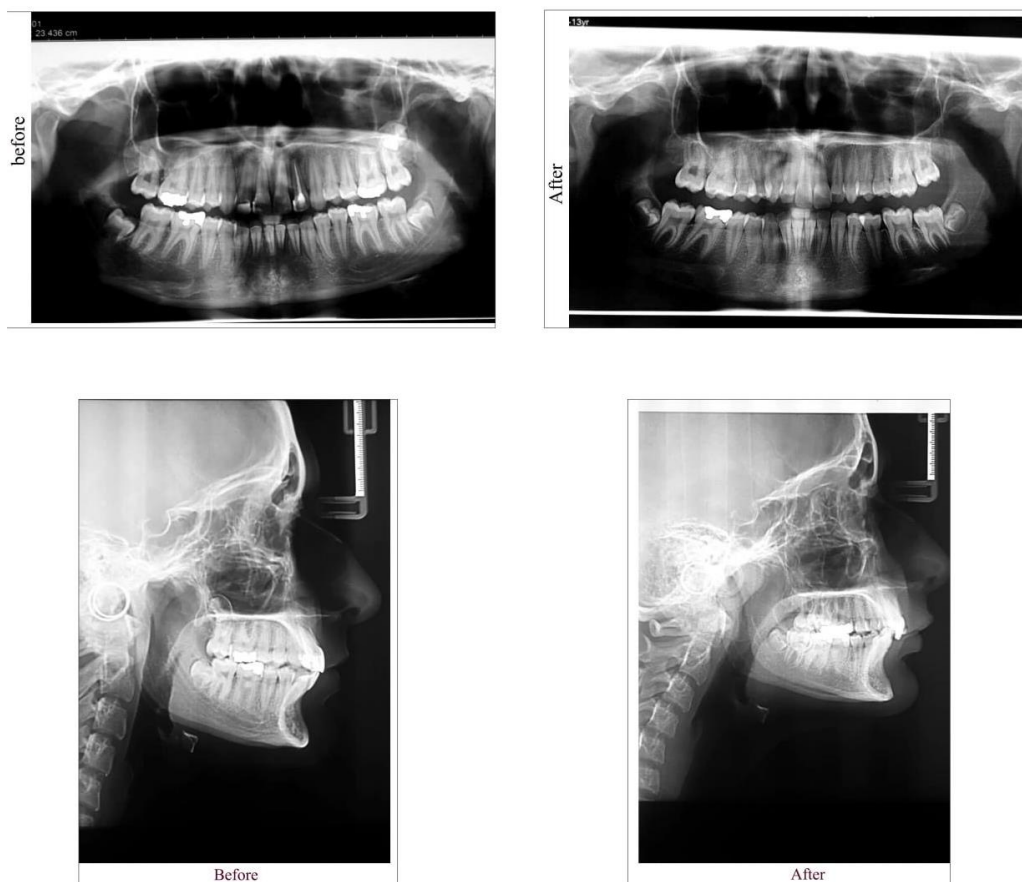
(Case III): Before and after treatment radiography in a 13 years old girl
